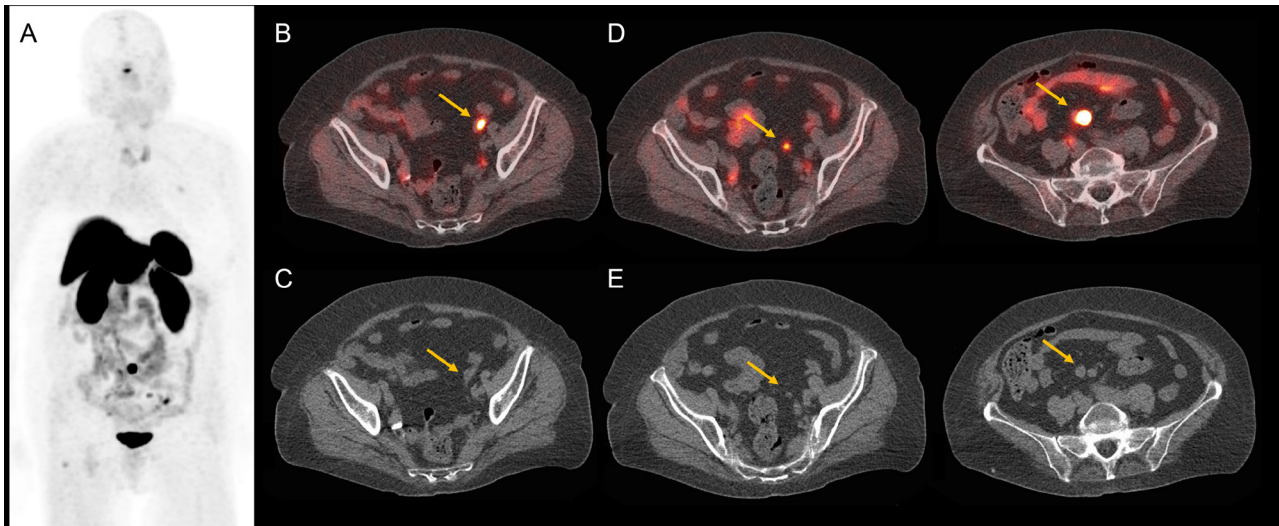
[^{68}Ga]Ga-DOTATATE PET/CT images. Maximum intensity projection (MIP) image (A) shows multiple sites of focal, strong increased uptake in the abdomen. Transverse sections of the fused PET/CT images (B and D) and the native CT (C and E) show strong focal uptake in the left fossa iliaca, on a small bowel loop (arrow), corresponding to the primary neuroendocrine tumor (B and C) and strong focal uptake in mesenteric lymph nodes (D and E), corresponding to lymph nodes metastases.
